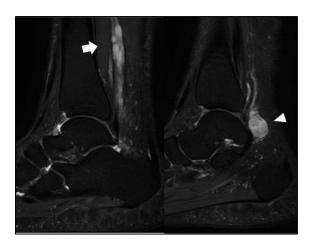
Sagittal T2-weighted image of the right ankle showing multinodular pattern (arrow) and round (arrow head) mass of the tibial nerve.
